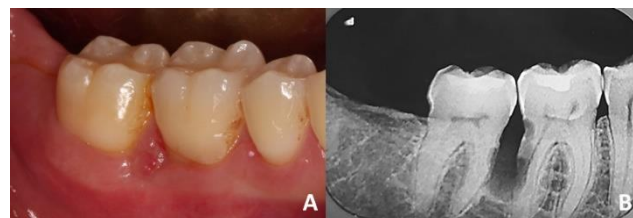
Initial assessment of the lesion. (A) Clinically, erosive lesion with normal color was observed in the interpapillary region of lower molars. (B) On periapical x-ray, it was possible to notice osteolytic lesion, with images suggestive of multiple foci of root resorption.
